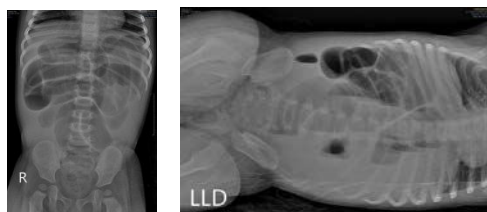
X-ray Abdomen, showed obstructive ileus
